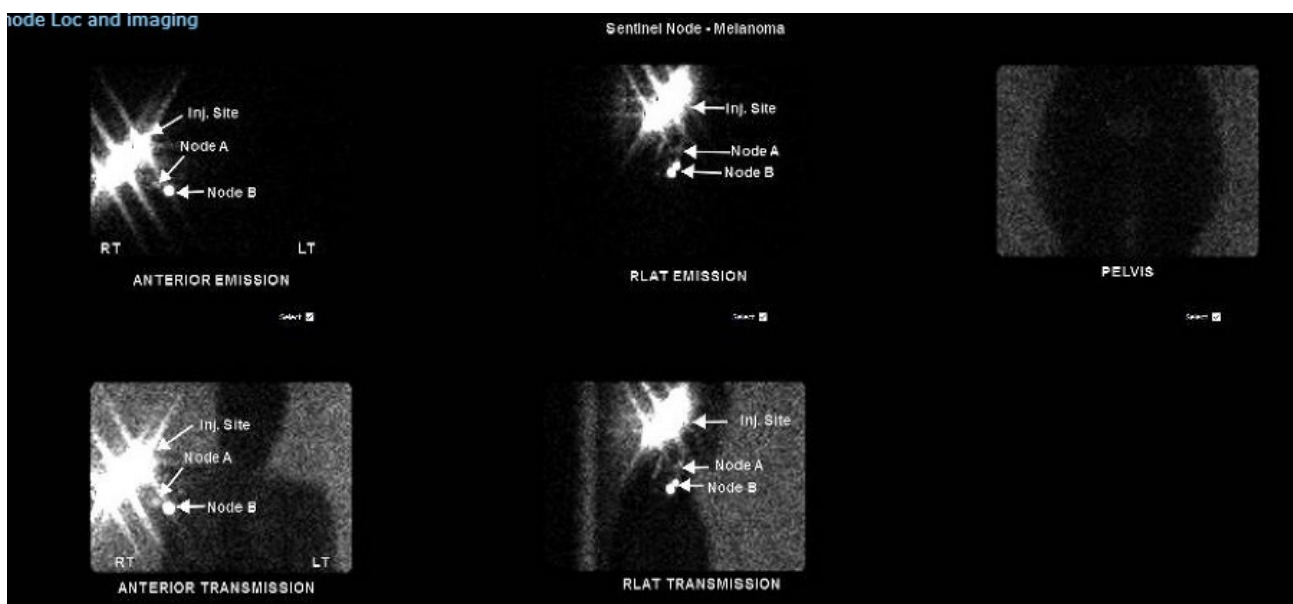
Post-wide local excision lymphoscintigram demonstrating 3 axillary sentinel lymph nodes.
